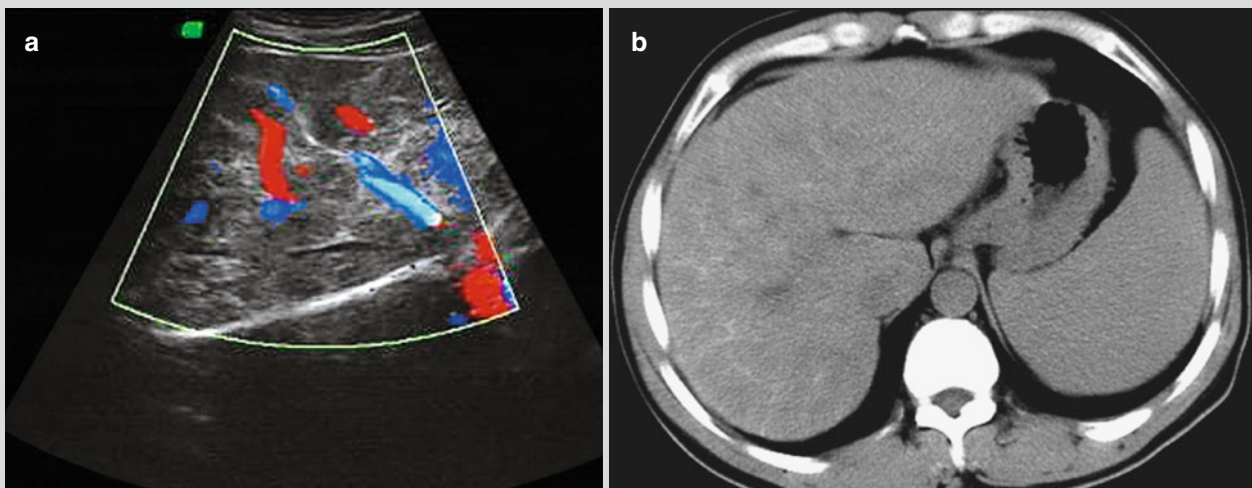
Hepatic schistosomiasis. (a) Ultrasound demonstrates unsmooth Glisson's capsule, thickened but uneven echoes from the liver parenchyma with maplike appearance, and poorly defined tubular
